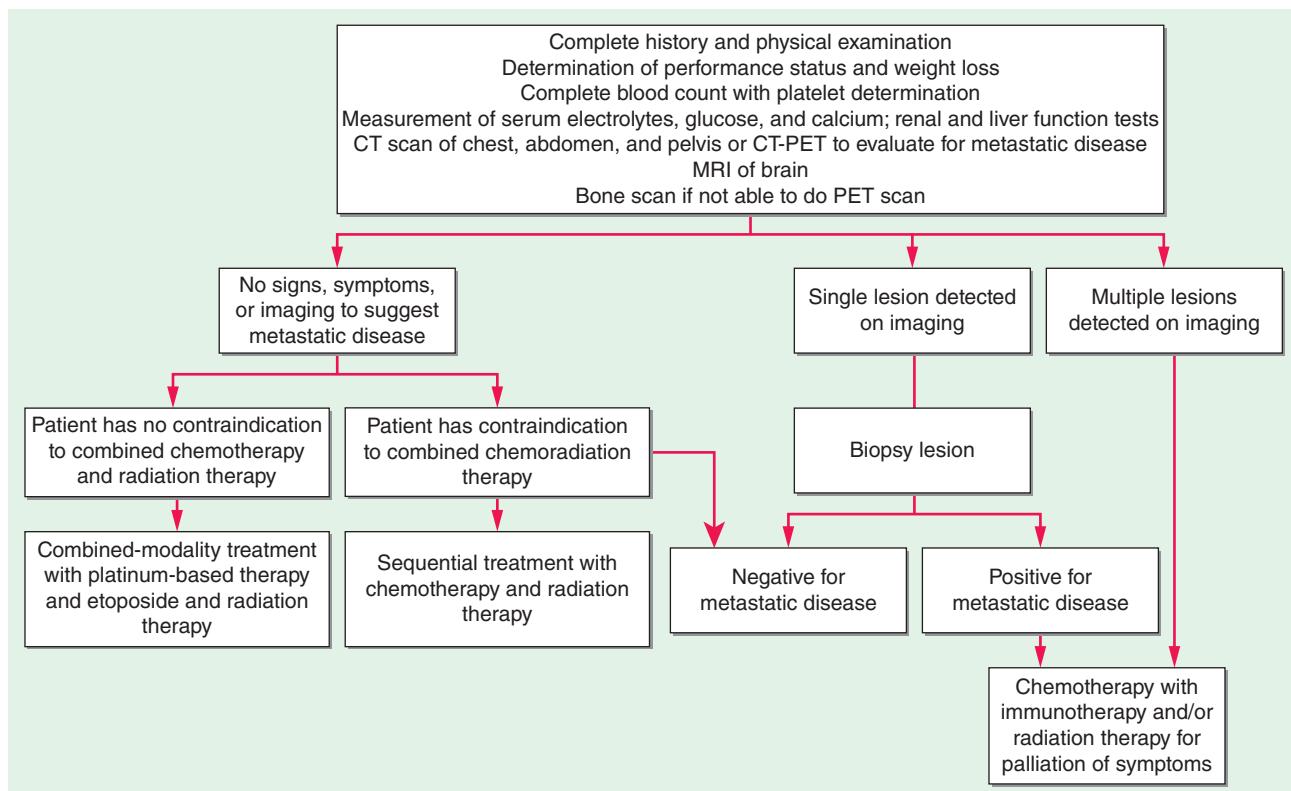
Algorithm for management of small-cell lung cancer. MRI, magnetic resonance imaging; PET, positron emission tomography.
